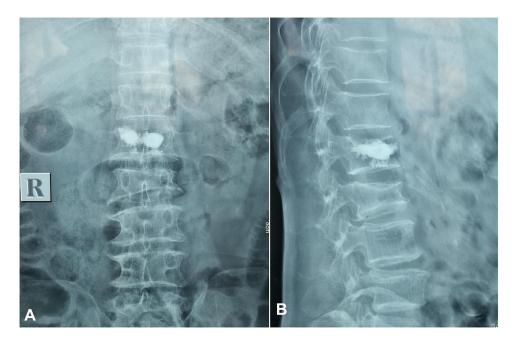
No intraspinal cement leakage was obvious on the anteroposterior (A) and lateral (B) view of the postoperative lumbar radiograph.
